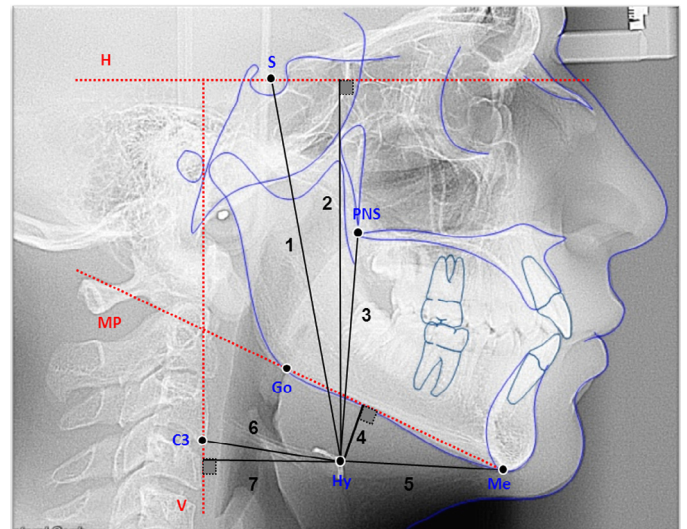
The figure shows the landmarks that were employed on a lateral cephalometric radiograph: H: most anterior point of the hyoid; S: midpoint of the sella tursica; posterior nasal spine (PNS): the spine-like projection from the posterosuperior midline of the horizontal plate of the palatine bone; C3: third cervical vertebra; gonion (Go): spine-like projection from the posterosuperior midline of the horizontal plate of the palatine bone; menton (Me): the most inferior point on the chin; MP: mandibular plane; V: vertebra. After that, linear measurements were obtained: H-S: linear vertical distance from H to S; H-PNS: linear vertical distance from H to PNS; H-C3: linear measure from H to the most anterior point of C3; H-MP: linear vertical distance from H to MP.
